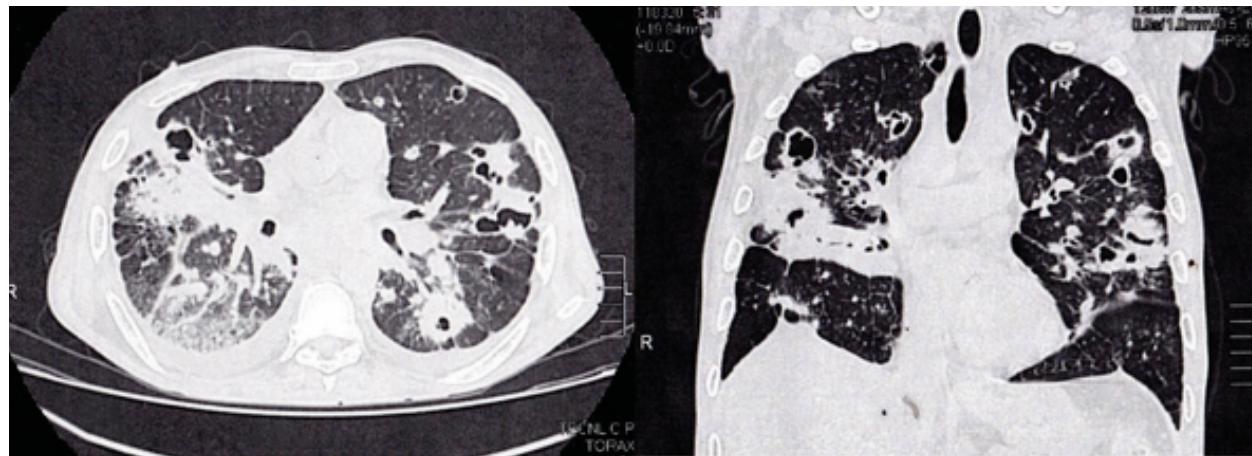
High-resolution computed tomography of the chest.
